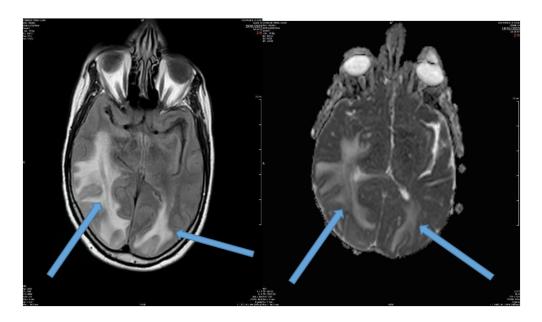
FLAIR and ADC from January 19, 2023.
